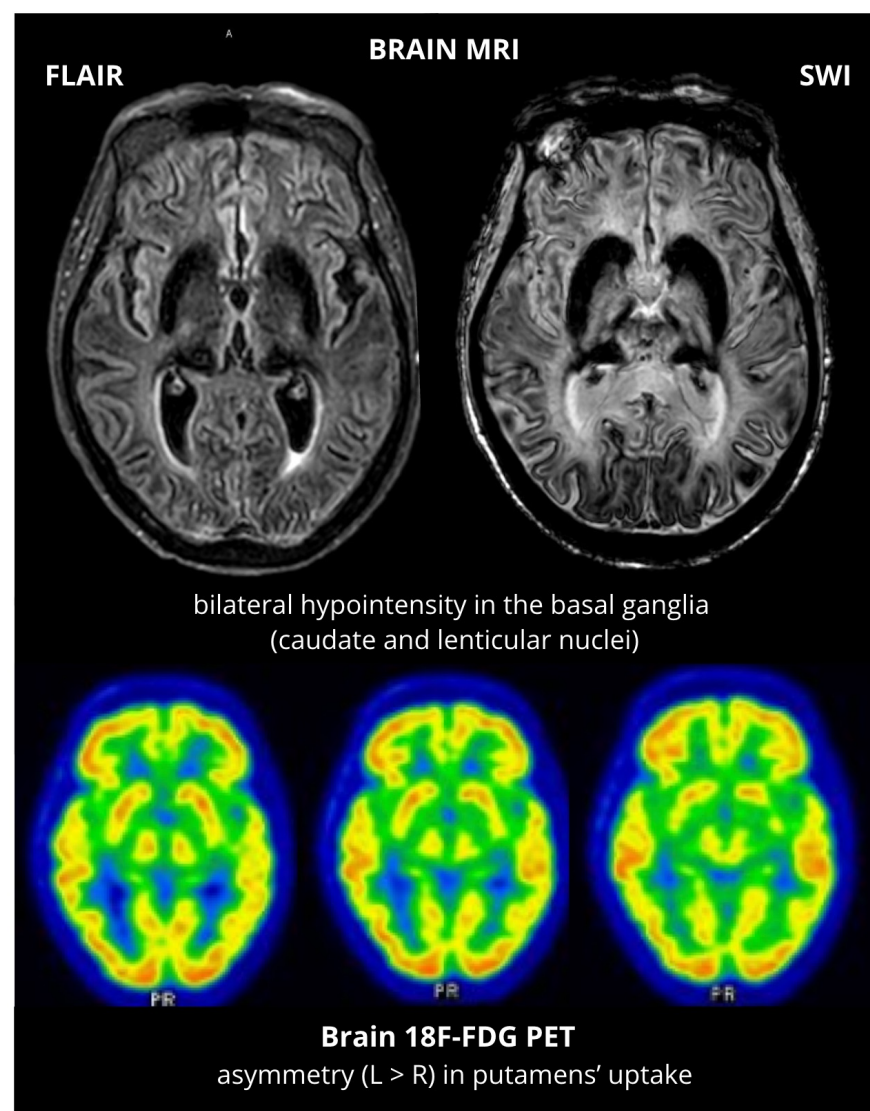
Brain MRI and brain 18F-FDG PET findings.
